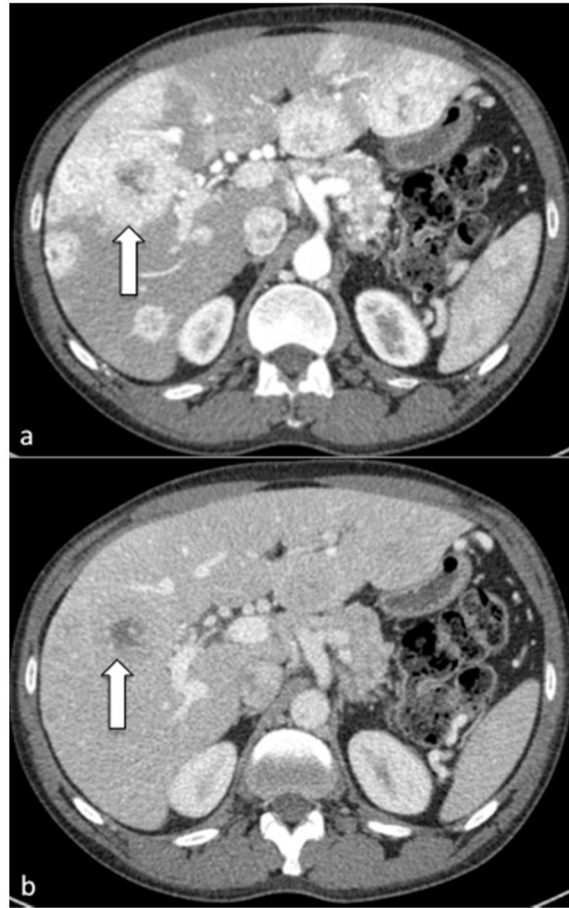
CT scan of a patient with a PNET and numerous hepatic metastases
